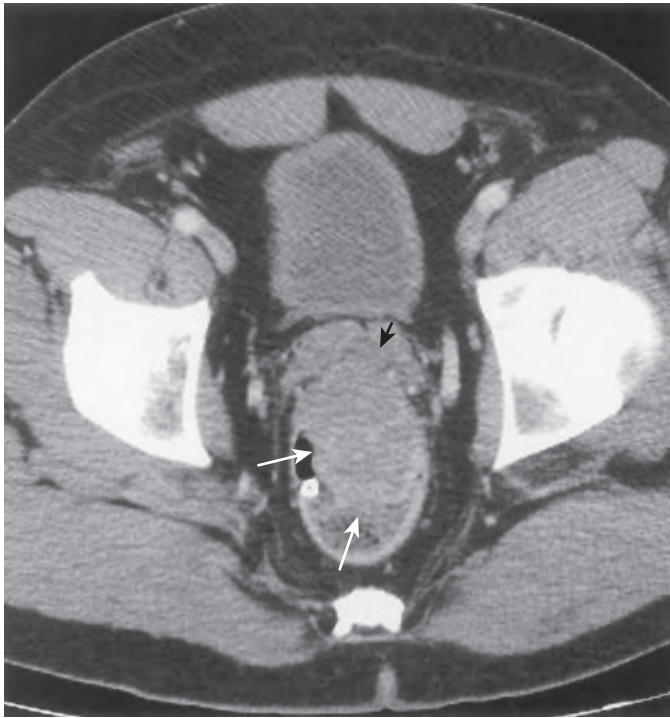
Malignant gastrointestinal stromal tumor of the rectum. CT scan shows a large soft tissue mass (white arrows) arising from the left anterolateral wall of the rectum. The mass enhances to the same degree as adjacent muscle. Infiltration of the fat plane between the rectum and seminal vesicles (black arrow) is present. (From Forbes A, Rubesin SE, et al: *Colon II*. In Forbes A, Misiewicz J, Compton C, et al [eds]: *Atlas of Clinical Gastroenterology*, 3rd ed. Edinburgh, Elsevier Mosby, 2005, p 183.)
